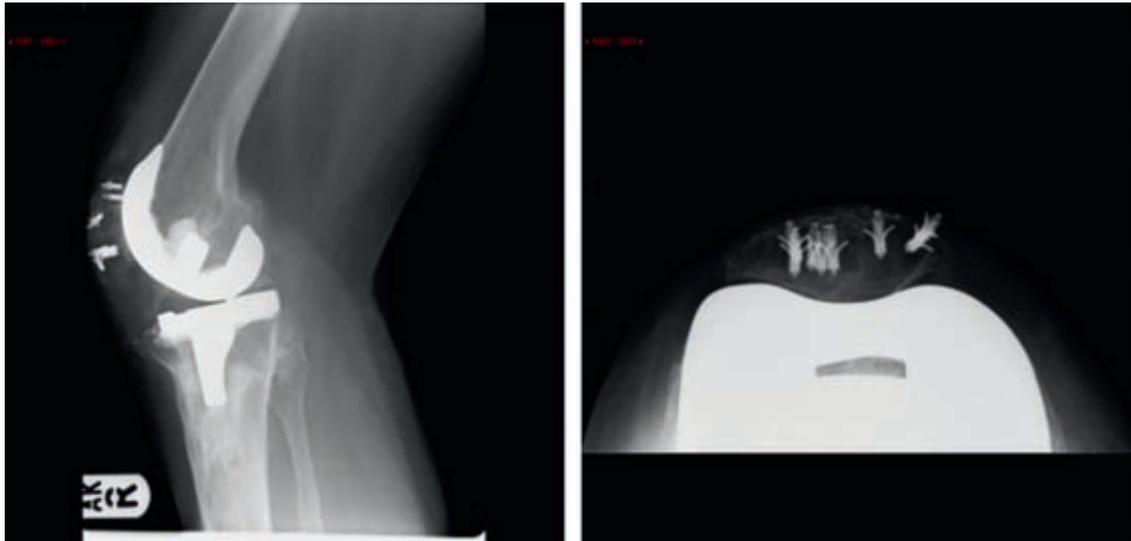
Lateral and 'skyline' radiographs of the right knee, at 34 weeks following suture anchor fixation.
